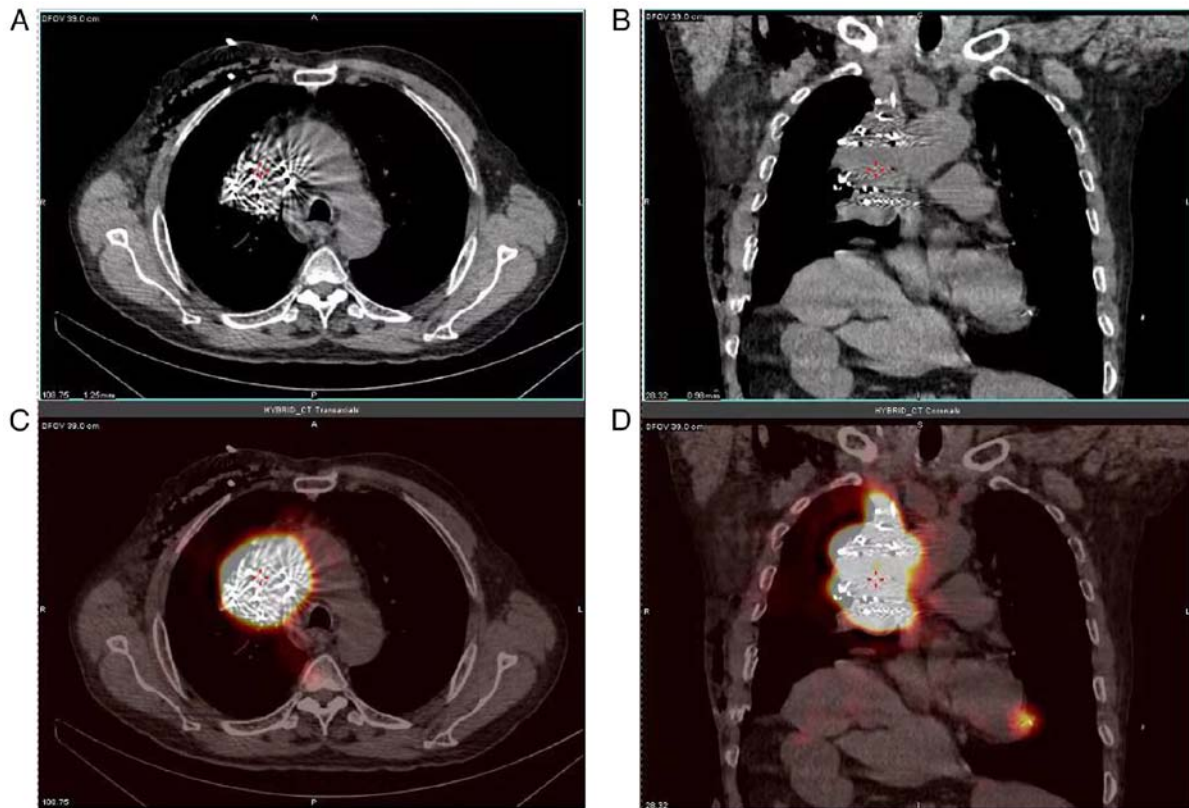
Postoperative SPECT particles cover the target area. (A) is the CT image (B) is the axial CT image immediately after particle implantation; (C) is relative SPECT showed that the radioactive concentration of particles basically covered the target area. (D) is the axial SPECT. SPECT, single photon emission computed tomography.
